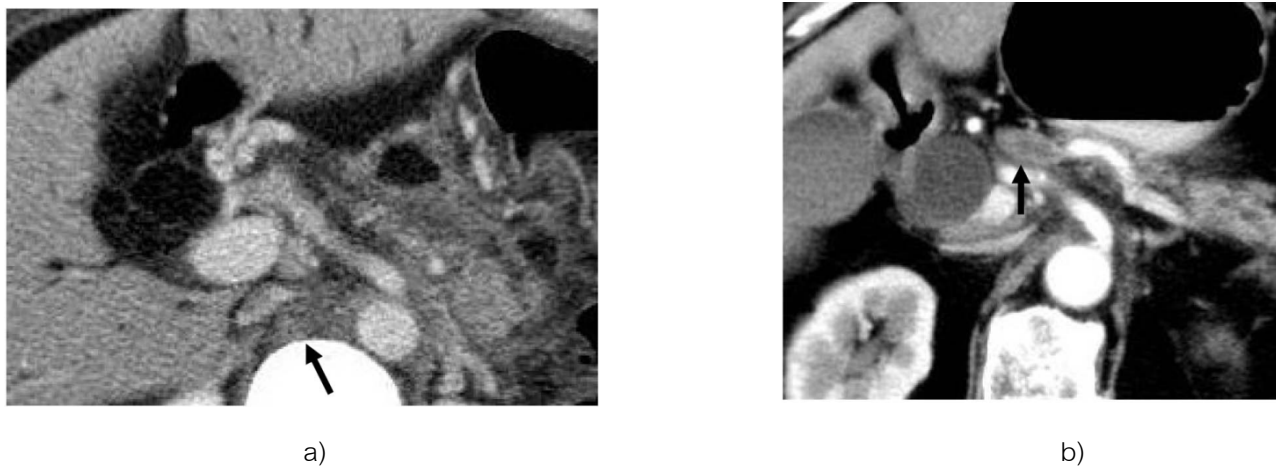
Regional node involvement. a) CT scan of a 62-year-old patient with diagnosis of well-differentiated pancreatic adenocarcinoma shows an enlarged aortocaval node (arrowed). b) CT scan of a 67-year-old reveals celiac node involvement with intranodal necrotic area (arrow).
